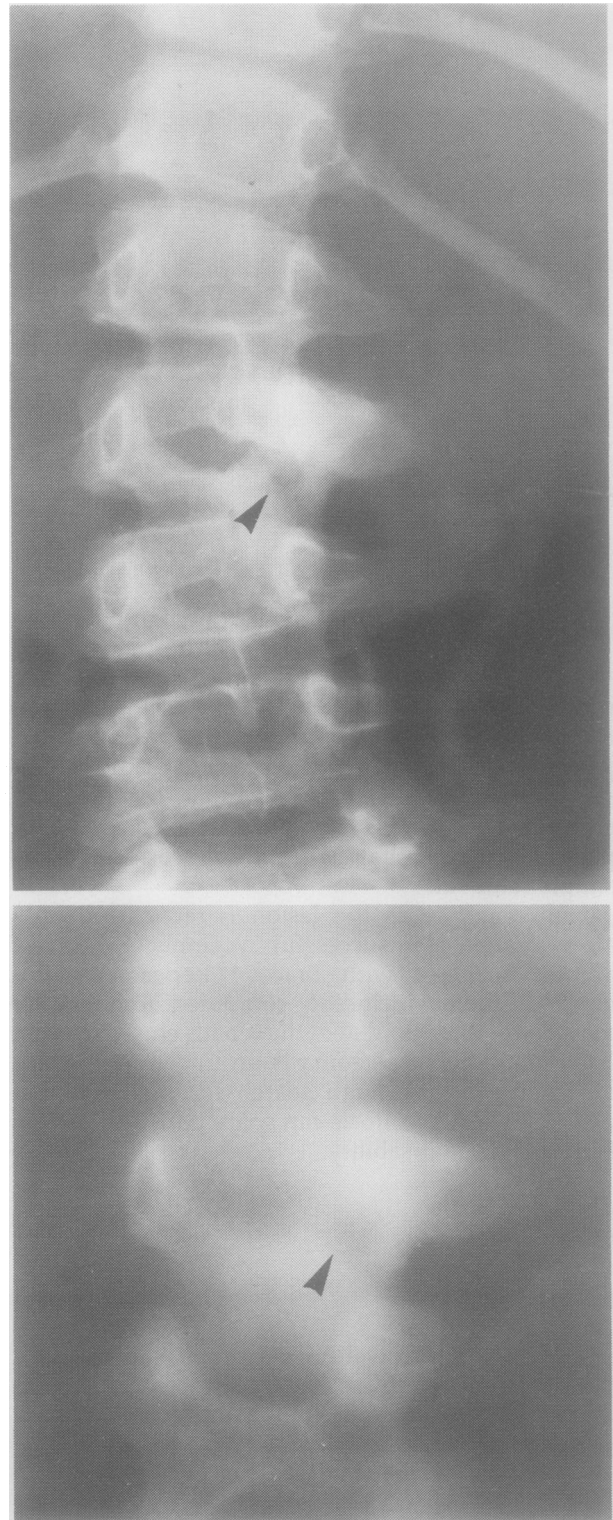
Case 3: Radiograph in top panel shows scoliosis of lumbar spine convex to left and sclerosis of second lumbar vertebra (L2). Tomogram in lower panel at 4.0 cm shows sclerosis of L2 involving right transverse process, pedicle, lamina and superior articular process. Arrows indicate central radiolucency in lamina.
